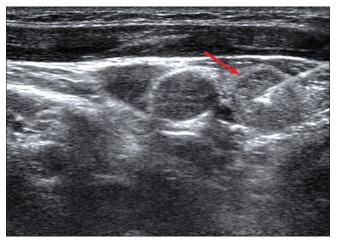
The ultrasound-guided fine-needle aspiration from a mildly hypoechoic solid nodule with a regular margin and a diameter of 9.5 mm (EU-TIRADS 4), which was proved by cytology to be a colloid nodule. EU-TIRADS: European Thyroid Imaging Reporting and Data System. Red arrow shows the nodule
